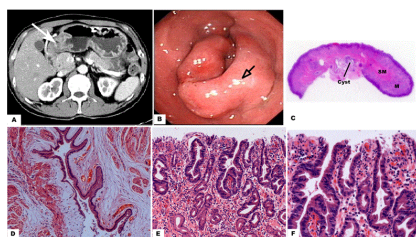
The cystic lesion of case 2. (A) Computed tomography revealed a well defined isodensity or slightly lower density mass of 3.0 in diameter, located at the greater curvature of the antrum, with uneven enhancement (white arrow). (B) The endoscopy showed a 3.0×3.0 protruding lesion (holly arrow) from the angular incisure to the antrum with erosive mucosa and stenosis. (C) Cysts located in the submucosa(sm) of the gastric wall. (D) The cyst has simple ciliated columnar epithelium lining inner, surrounded with smooth muscle. No sign of dysplasia or carcinoma in situ was investigated (HE, $\times 40$). (E) Early adenocarcinoma in the gastric glands of the adjacent gastric wall can be seen (HE, $\times 100$). (F) The epithelium of the gastric wall was characterized by pseudostratification, with depletion of mucin and nuclear hyperchromatism, which penetrated to the lamina propria, indicating high grade neoplasia lesion (HE, $\times 200$).
